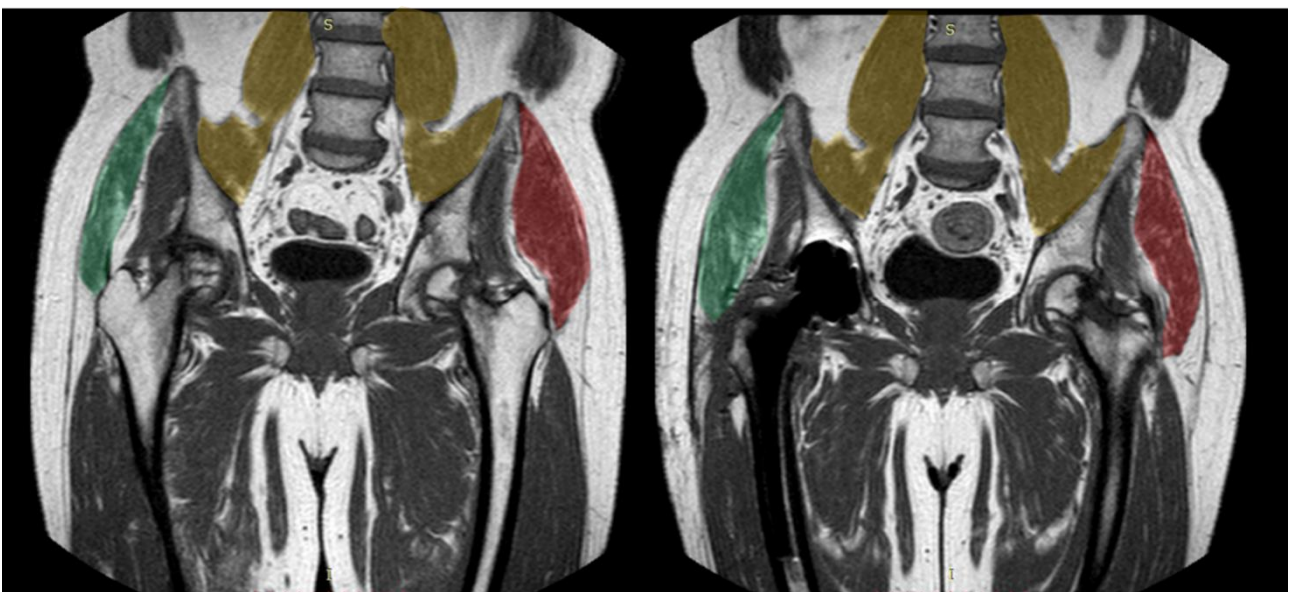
Example of muscle volume segmentation: (A) T1-weighted coronal MRI scan of the pelvic area with coloured manually drawn boundaries of the muscles of interest. (B) 3D muscle geometry reconstructed via interpolation of consecutive 2D segmentations; the IP volume was considered distal to the iliac crest, as represented in green in the B image. MRI = Magnetic resonance imaging, IP = Iliopsoas.
